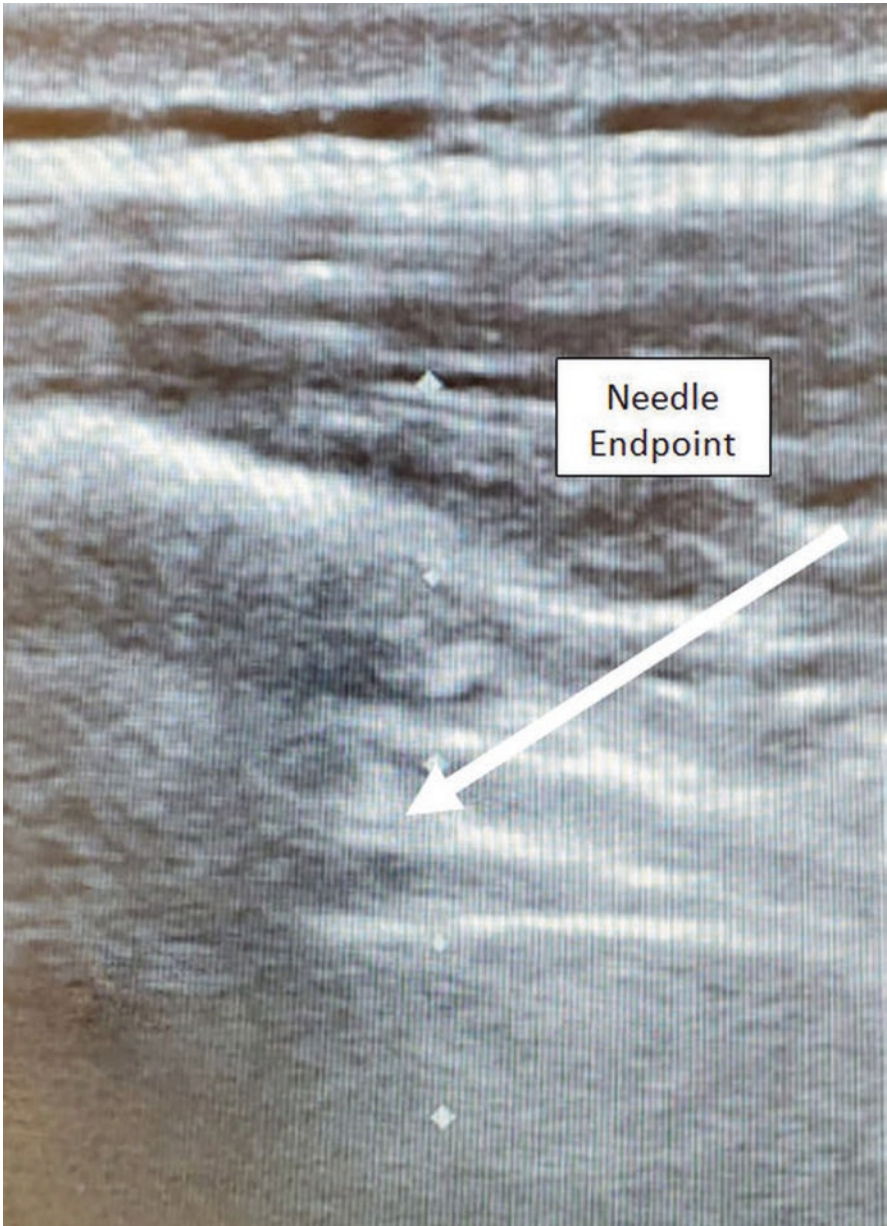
Ultrasound-guided In-plane Approach. Patient is placed in the prone position with ultrasound probe placed in a sagittal and slightly oblique tilt
